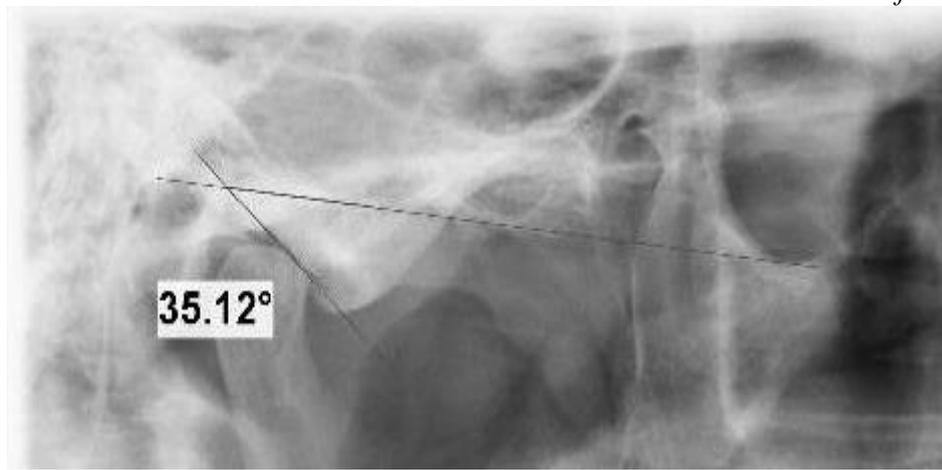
Determination of condylar guidance by panoramic radiography.
